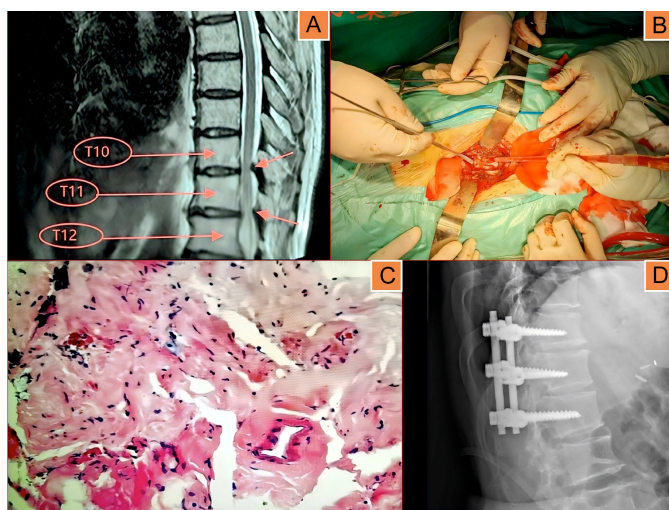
(A) Thoracic MRI shows calcification or ossification of the ligamentum flavum at T11-T12 levels, leading to lumbar spinal stenosis and spinal cord compression. (B) The vertebral canal corresponding to the thoracic 11 and 12 vertebrae was incised with an ultrasonic bone cutter. (C) Postoperative pathological examination showed that the tissue taken was ligamentum flavum with collagen fibres with calcification or sclerosis. (D) Postoperative thoracic x-ray showing the internal fixation hardware in the correct position.
